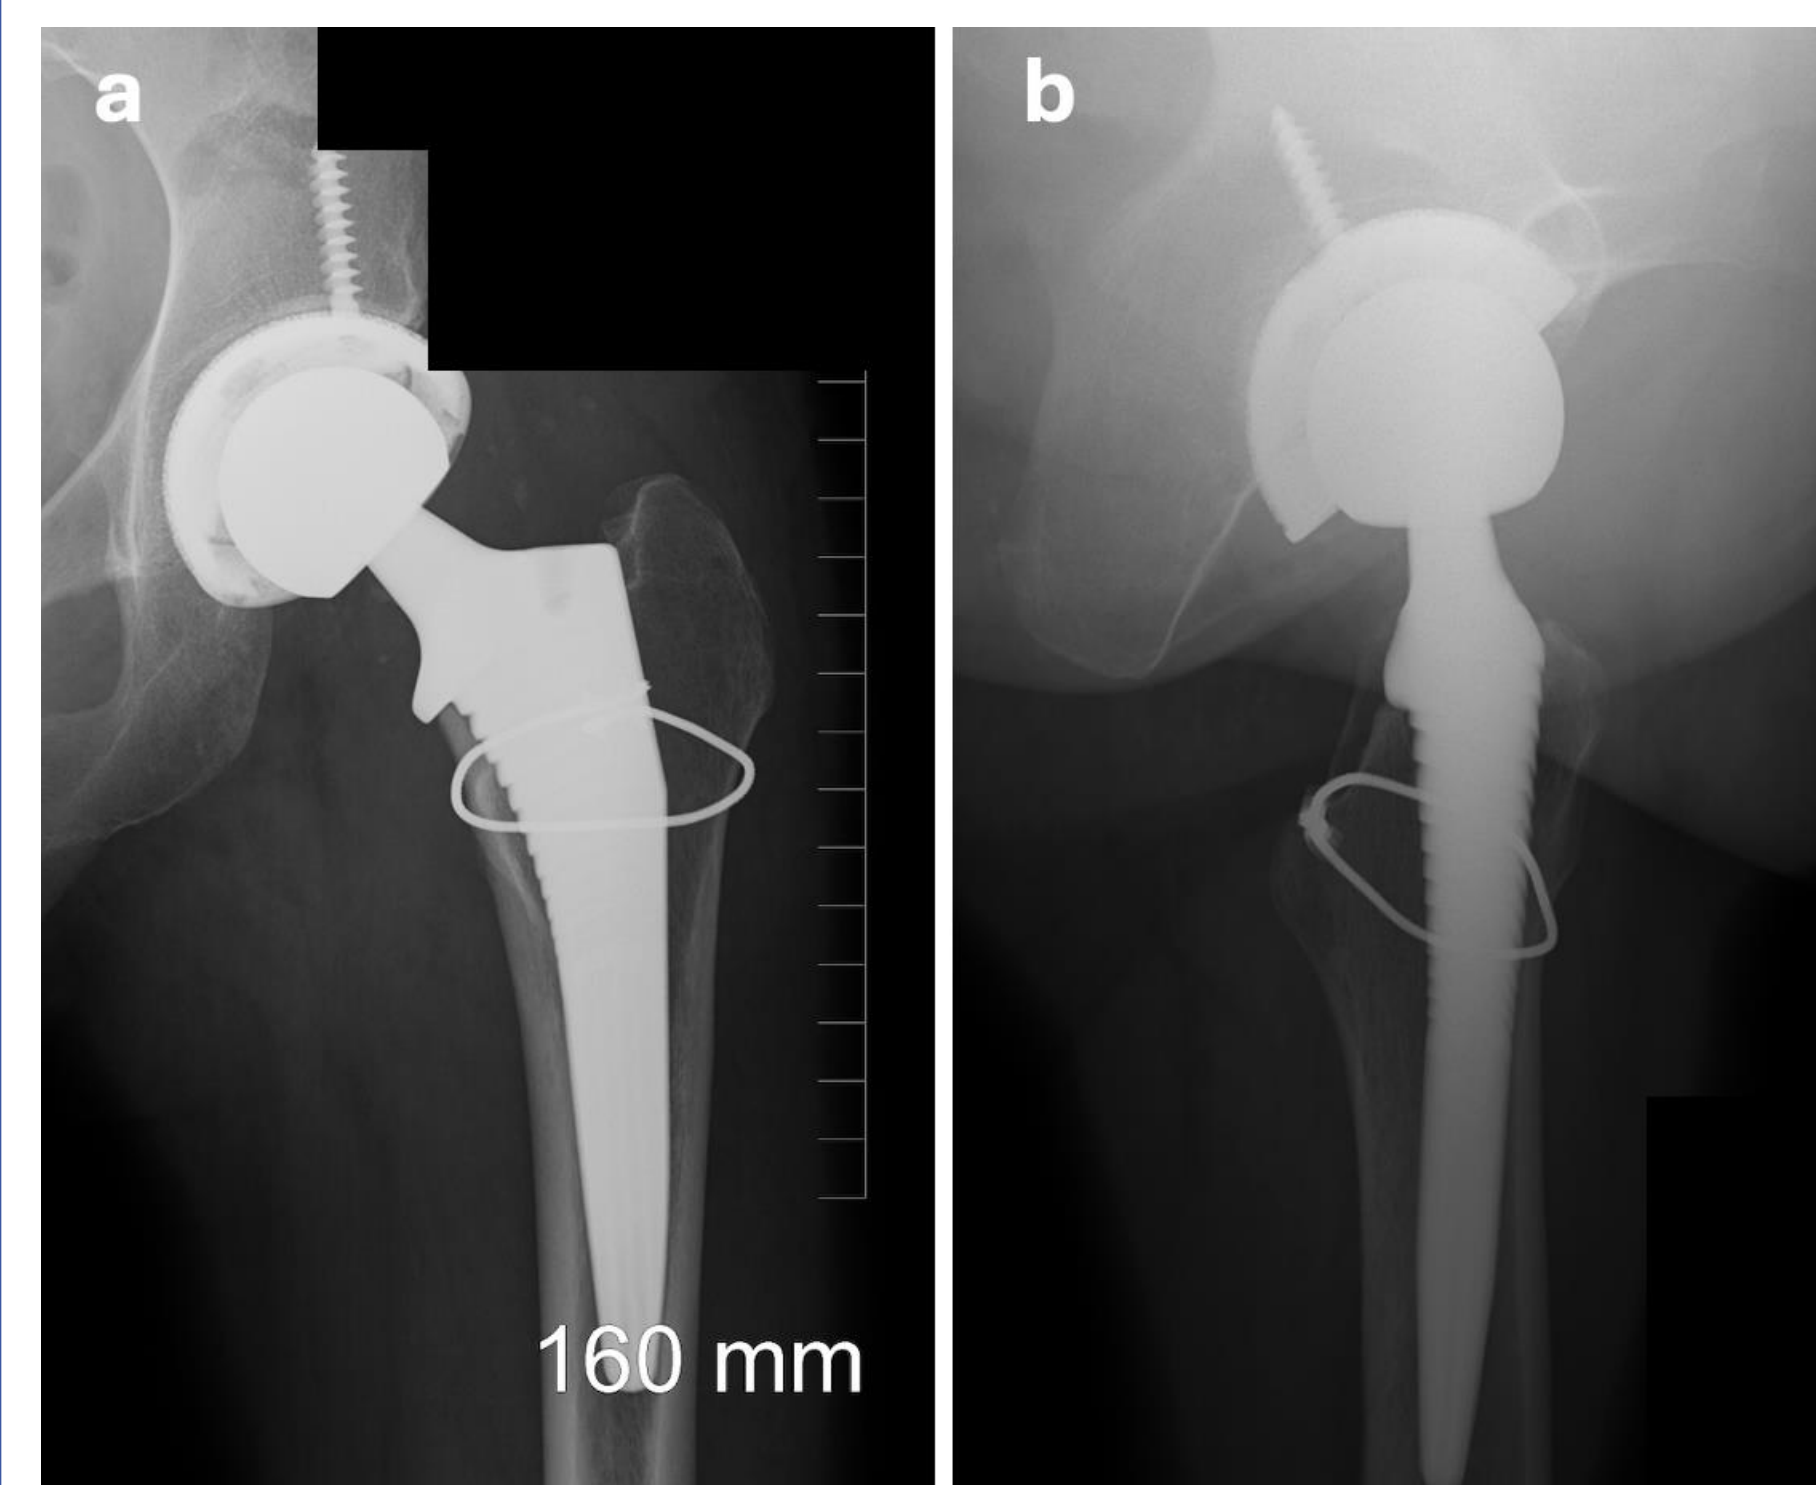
Anteroposterior (a) and cross table lateral (b) radiographs of the left hip at two-week follow-up revealed intact left total hip arthroplasty device with cerclage wire about the femoral component without evidence of loosening or subcutaneous edema.
